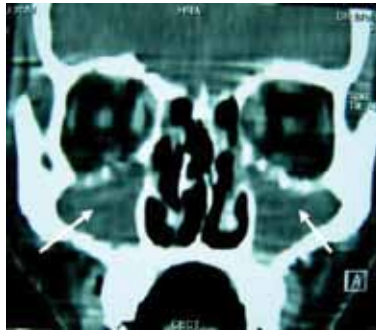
Computed Tomography of the paranasal sinus showing bilateral maxillary sinus opacification with bone irregularity
